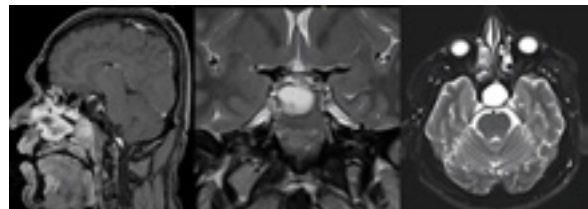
Preoperative MRI (patient number 2) A. Sagittal section B. coronal section C. axial section
